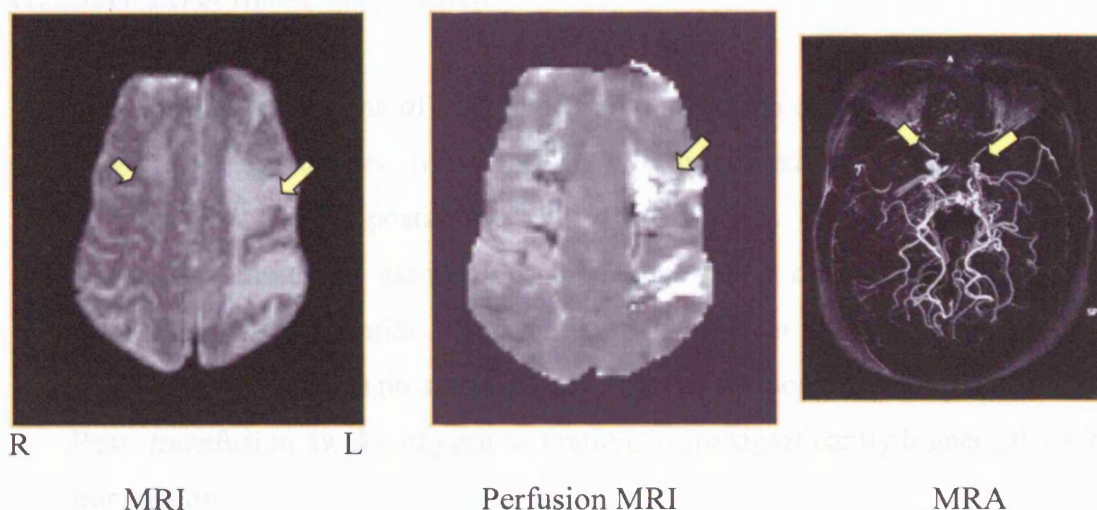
Long-Term blood transfusion. 21-year old female, severe SCD (HbSS), bilateral MCA stroke, leg ulcers, on chronic blood transfusion. T2-w MRI. Middle cerebral artery (MCA) infarction bilaterally (left > right). Abnormal Perfusion MRI. Increased mean transit time of the passage of IV contrast bolus in the MCA territories bilaterally more on the left than the right. MRA. Occlusion of the right MCA & anterior cerebral artery (ACA), severe turbulence in the left MCA and moyamoya collaterals. R: right; L: left.
